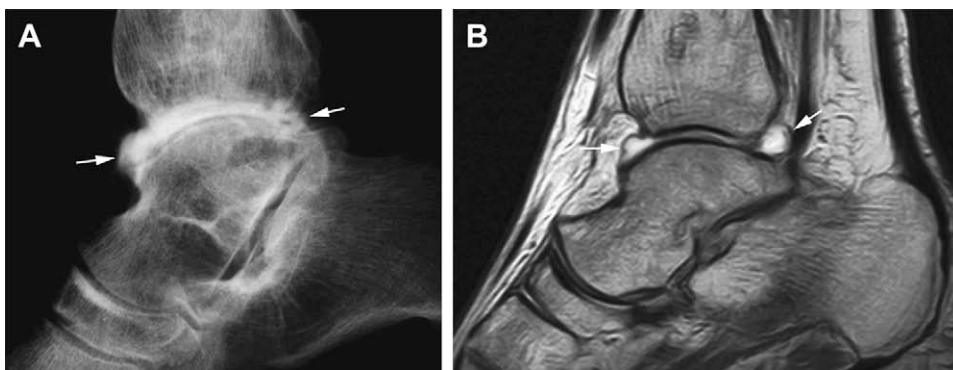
Adhesive capsulitis of tibiotalar joint. (A) Lateral ankle arthrogram and (B) sagittal T1-weighted MR arthrogram of the right ankle in a patient previously surgically treated for bimalleolar fracture show restricted filling of the anterior and posterior capsular recesses (arrows). A decreased joint volume (4 mL) was encountered during arthrography as well.
